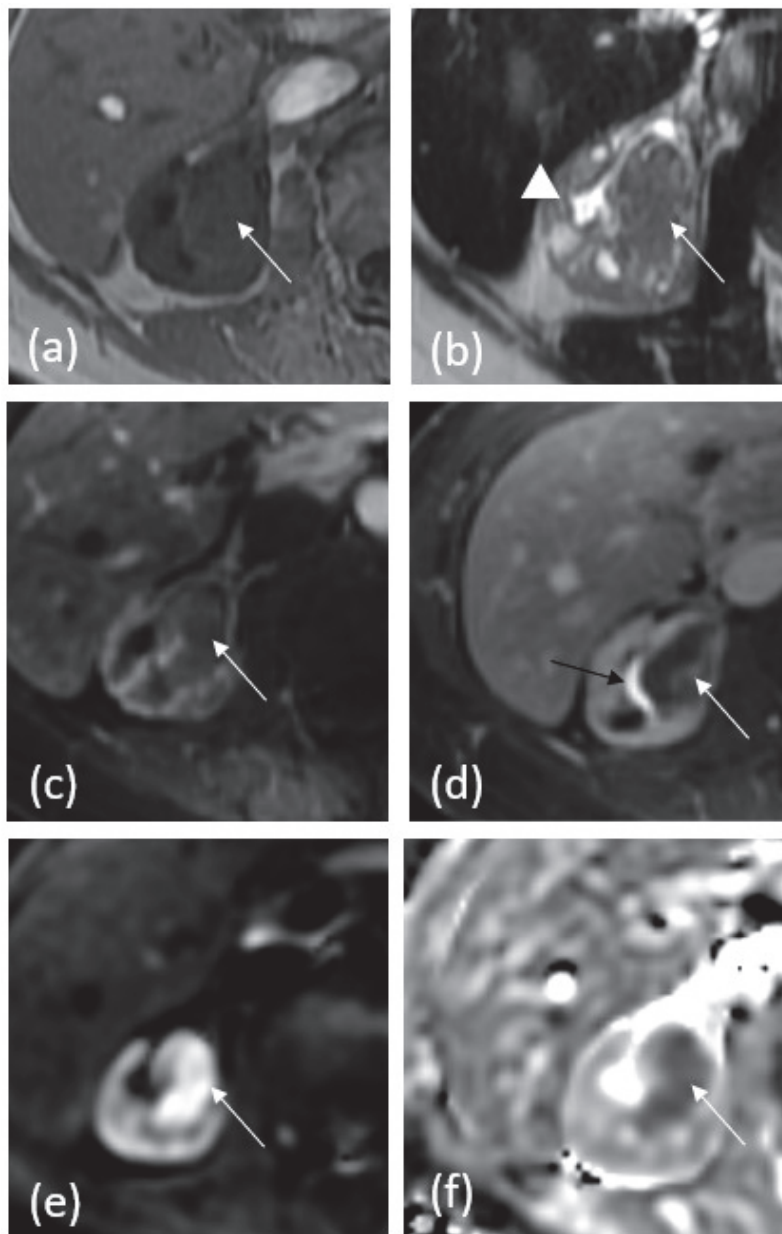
A 64-year-old female with history of right renal mass. (a) T1 pre-contrast demonstrates isoechoic mass (white arrow) in the renal pelvis with obliteration of multiple calyces. (b) T2-weighted image demonstrates iso- to hypoechoic mass signal again with obliteration of normal calyces and mild associated hydronephrosis (white arrowhead). (c) Fat-saturated T1 post-contrast corticomedullary phase demonstrates subtle heterogeneous enhancement within the mass. (d) Fat-saturated T1 post-contrast 5 min delayed phase delineates the tumor better, which is enhanced less than adjacent renal parenchyma is. Excreted contrast is noted in the collecting system (black arrow). (e) Diffusion-weighted images show increased signal within the mass. (f) ADC map shows dark signal in the mass, confirming restricted diffusion.
